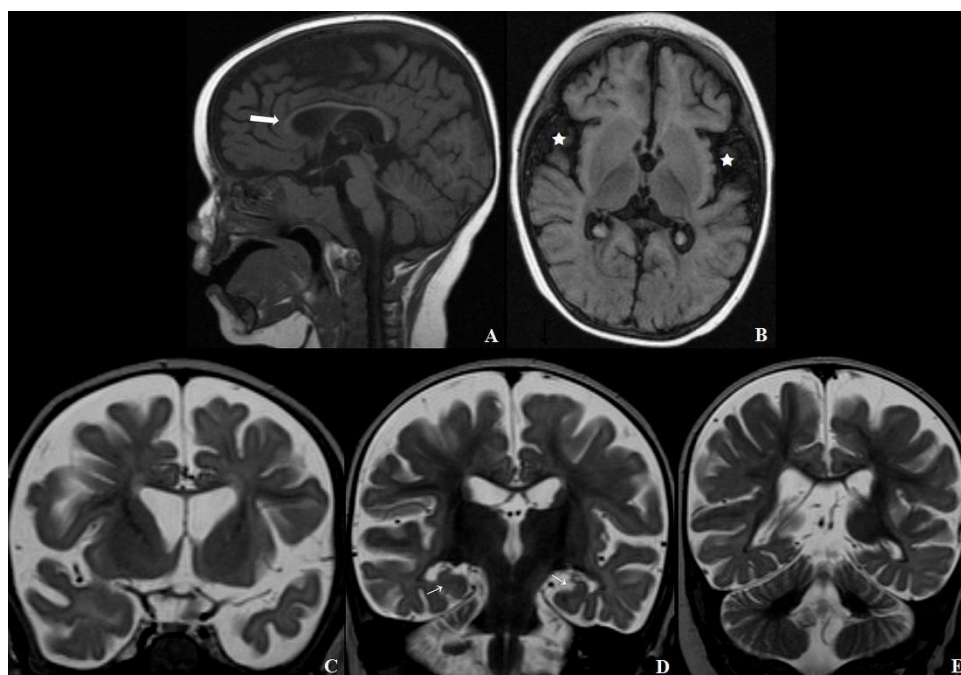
MRI images of the brain before cobalamin supplementation. The supratentorial brain compartments, particularly the temporo-insular regions on both sides (Panel B, axial T1 SE) (white stars), were underdeveloped. The corpus callosum was abnormally thin for the patient's age (Panel A, sagittal T1 SE) (white arrow). The underdevelopment of the supratentorial brain is evident in all Panels (C, D and E, coronal T2 SE) and Ammon's horn is difficult to recognize (thin white arrows).
